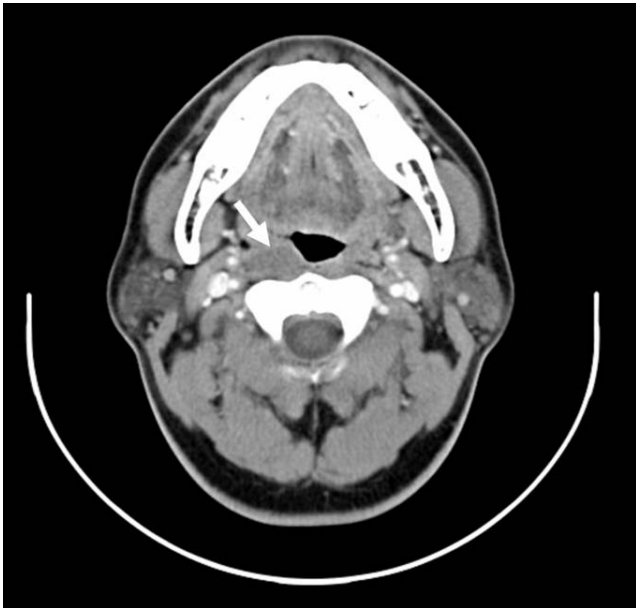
A 45-year-old man with right retropharyngeal bronchogenic cyst. Axial CT scan demonstrates an ovoid hypodense mass (arrow) in the right retropharyngeal space.
